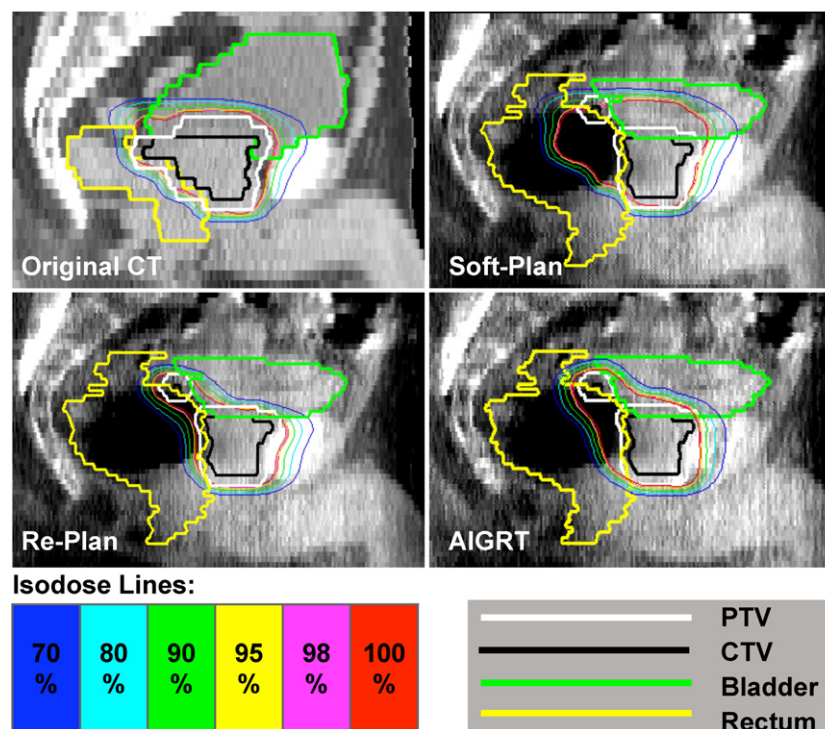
Plan comparison between *Soft-Plan*, *AIGRT* and *Re-Plan* for OAR sparing in an example case where daily CTV is significantly deformed compared to that in the original CT plan. The *Soft-Plan* plan is generated by shifting the original CT plan to match soft tissues in the daily CBCT image. The *AIGRT* plan is selected by our algorithm from previous plan library. The *Re-Plan* plan is generated by complete re-optimization based on the CBCT image. Isodose lines on *Soft-Plan*, *Re-Plan* and *AIGRT* are calculated for each plan using the same CBCT image set.
